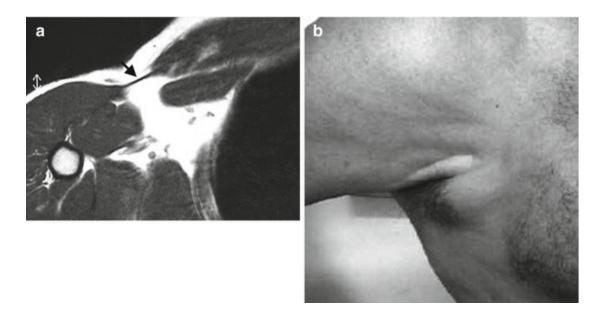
A 38-year-old-man with a chronic rupture of the myotendinous junction. Axial T1-weighted MRI shows a thin tendon (*arrow*, a) without frank discontinuity, suggesting a high grade tear that leads to aesthetic deformity of the chest wall as shown in this picture (b)
